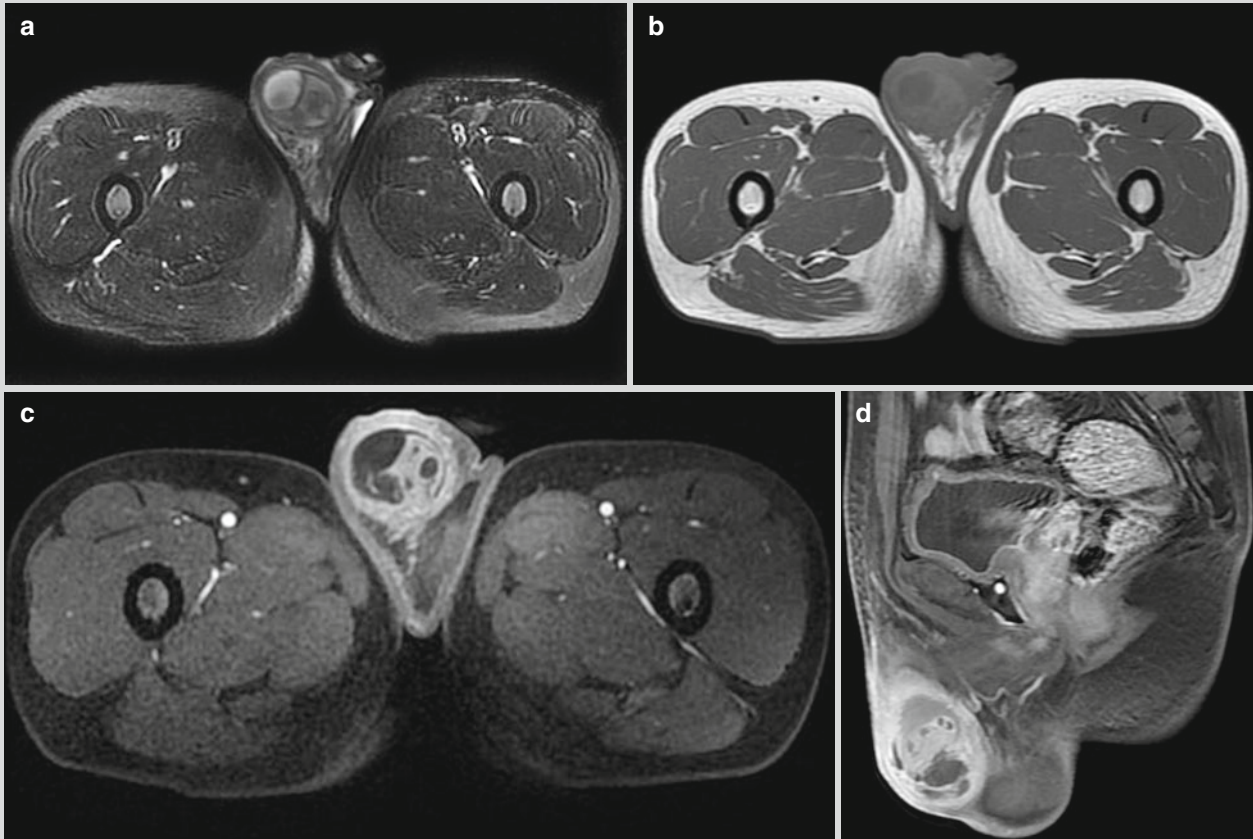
Brucellosis complicated by testicular lesion. (a–d) MR imaging demonstrates swollen testicles with uneven long T1 and long T2 signals. By contrast imaging, enhanced septum is demonstrated
